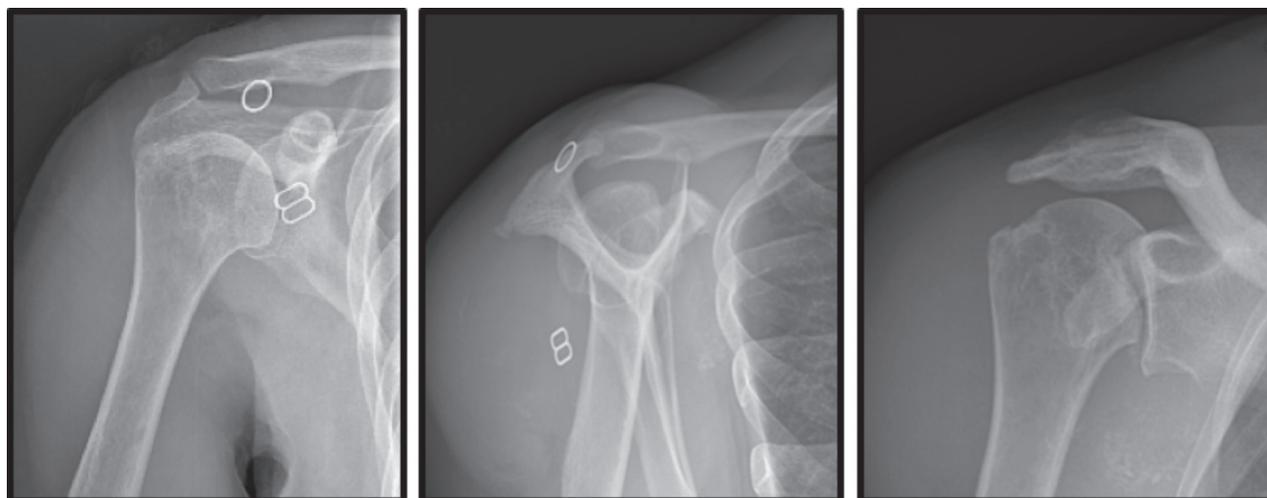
On the left: radiograph before posterior dislocation. On center and the right: right posterior shoulder dislocation
